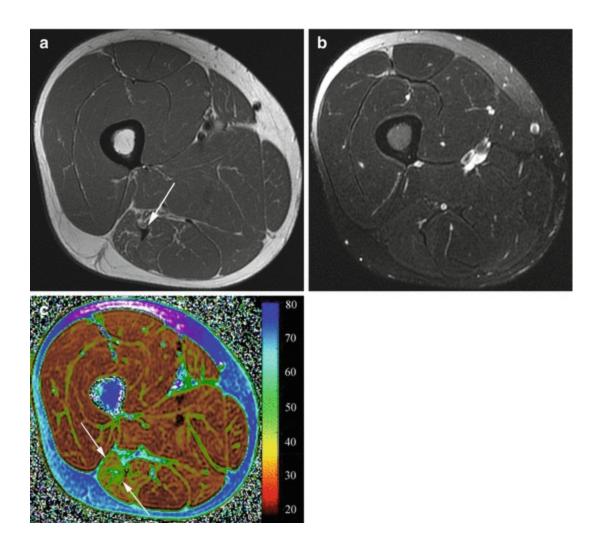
Professional 29-year-old soccer player with a history of a strain of the long head of biceps femoris (LHBF) muscle 10 weeks prior. (a) Axial T1-weighed MRI shows mild chronic changes with thickening of the LHBF tendon at the proximal myotendinous junction (arrow), without significant changes in the adjacent muscle bulk. (b) Axial fat-suppressed T2-weighted MRI does not demonstrate signs of edema in the LHBF muscle. (c) Axial color-coded T2 map of the thigh demonstrates an increase in T2 values of the LHBF muscle (green color, arrows) when compared to other muscles in the field of view, which may be related to early fat atrophy of the muscle
